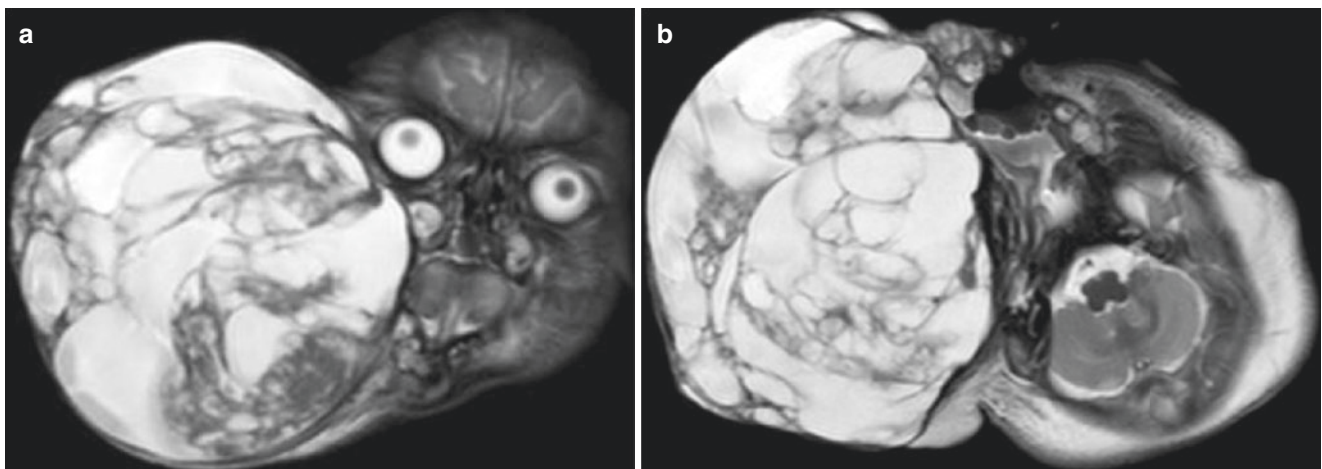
Congenital cervicofacial teratoma on post-natal MR imaging. T2-weighted coronal (a) and axial (b) images show a complex lesion containing cystic and solid elements arising from the right side of the face and neck
